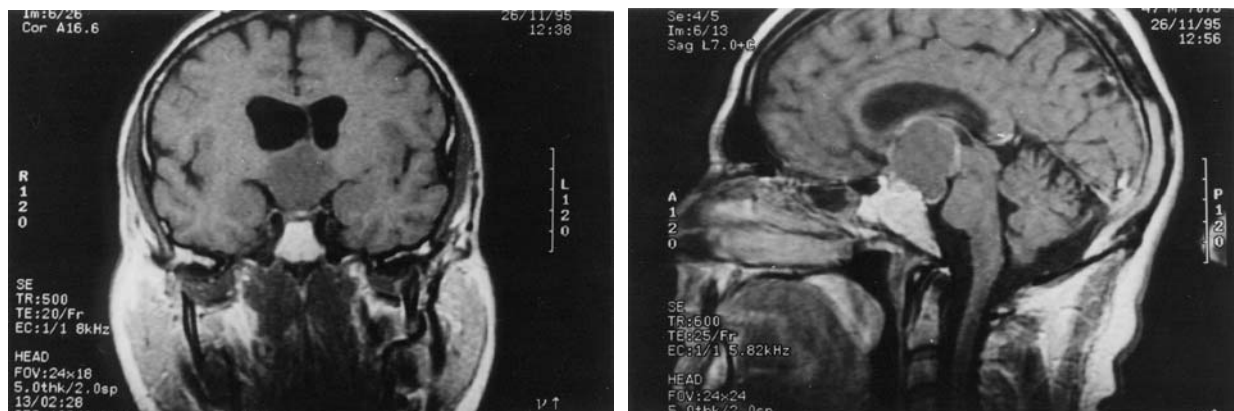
T1-weighted magnetic resonance image showing a suprasellar-third ventricle hypo-intense lesion. *Left*: coronal section demonstrating preservation of the lateral wings of the suprasellar cistern (TR 500 msec, TE 20 msec); *Right*: sagittal section after gadolinium administration showing ring enhancement and a pot belly expansion reaching the prepontine cistern; pituitary gland is intact. (TR 600 msec, TE 25 msec)
